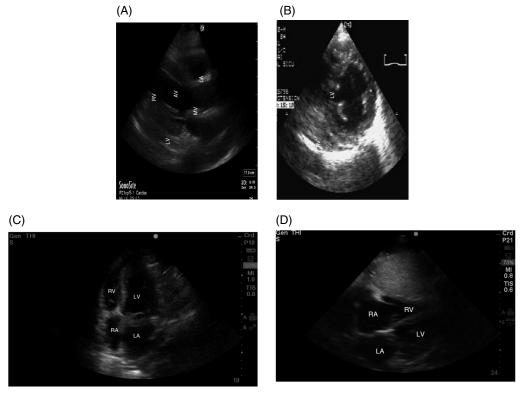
Standard bedside ECHO views. (A) Parasternal long axis, systole; aortic valve open, MV closed. (B) Parasternal short axis, mid-papillary muscle level. (C) Apical four chamber view. (D) Subxiphoid view.
